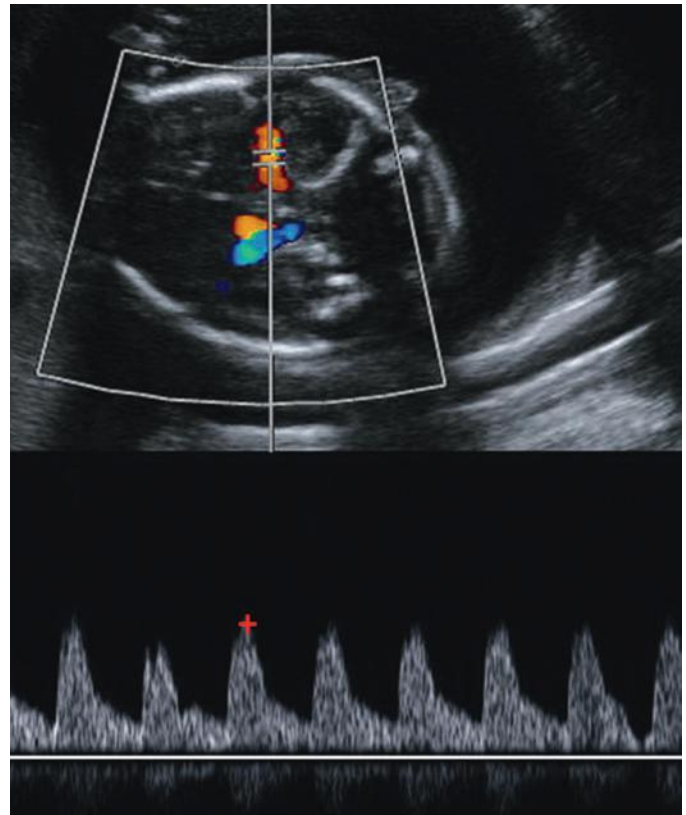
Doppler imaging and measurement of peak systolic velocity in the fetal middle cerebral artery.
